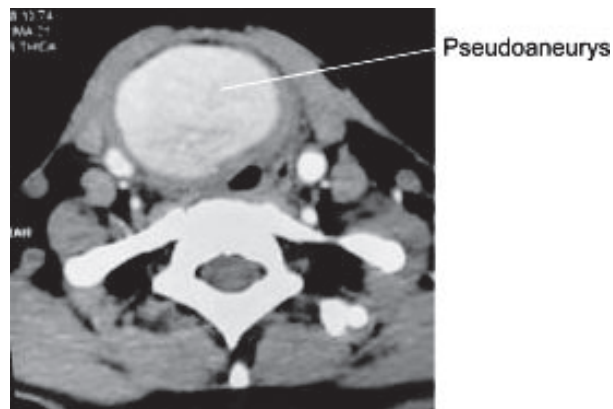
Post contrast CT scan of neck showing intensely enhancing pseudoaneurysm arising from proximal part of right CCA.
